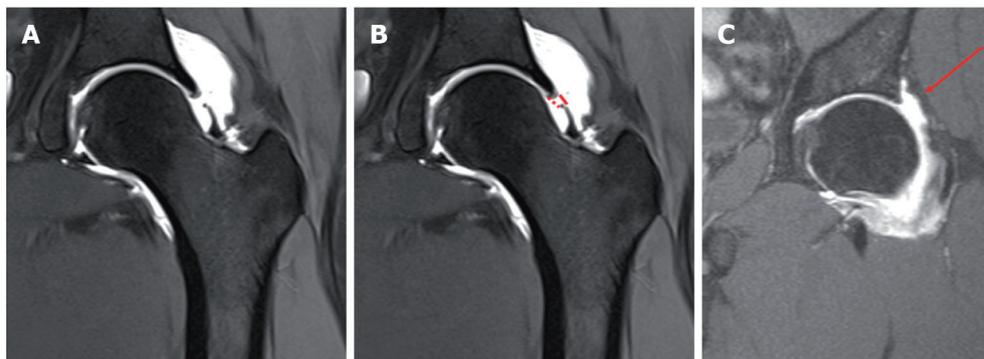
Example of capsular defect and intact capsule on magnetic resonance imaging-arthrography.
